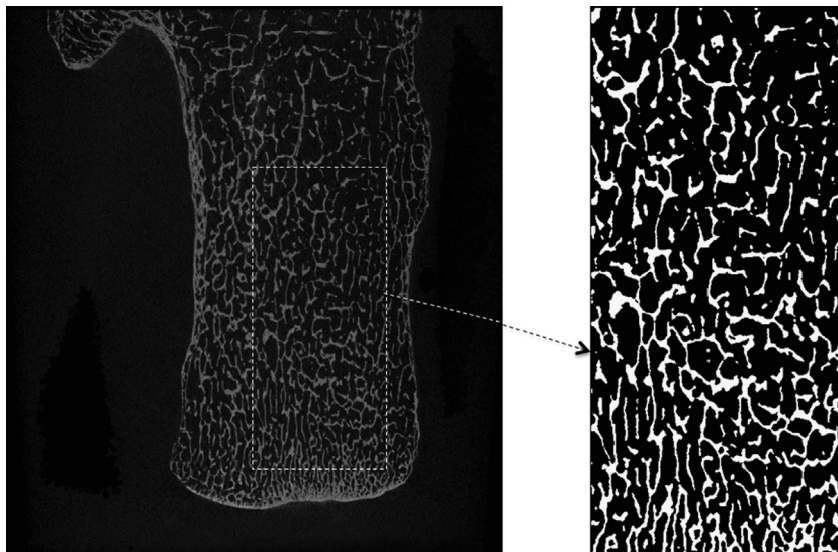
Left: CT-scanned image of human calcaneus. Right: binary mapping of a rectangular 1 cm \times 2 cm cross-section along the calcaneal bone. The white area is the trabecular matrix while the black area is the interstitial space.
